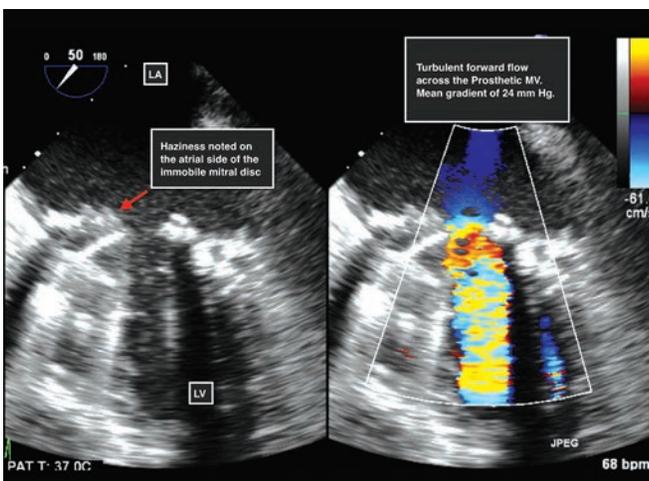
2D transesophageal echocardiographic view of the prosthetic mitral valve. Haziness noted over the atrial side of the prosthesis (left). Turbulent forward flow across the prosthetic mitral valve with measured mean gradient of 24 mm Hg (right).
